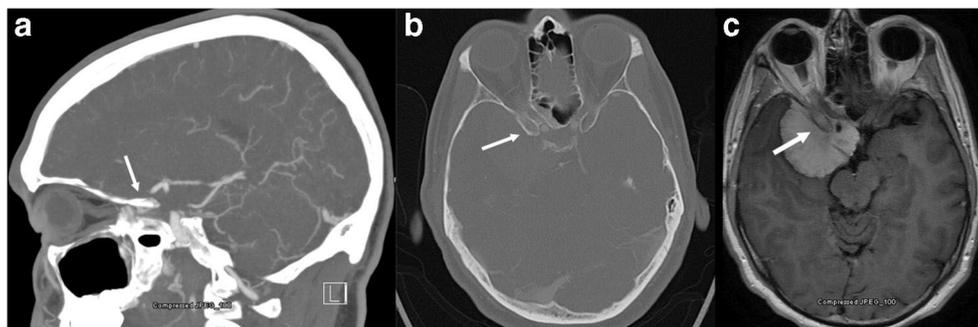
Extradural clinoidectomy in a patient with a meningioma. a Sagittal CT, b axial CT, and c axial MRI with gadolinium of the patient in the video demonstration. The patient had a large medial sphenoid wing
